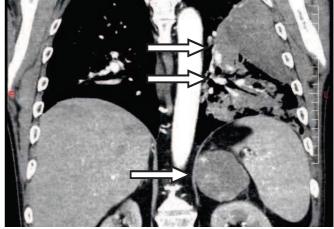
A CT scan demonstrating the left adrenal gland mass (single arrow) and consolidation of the left lung (double arrows).
